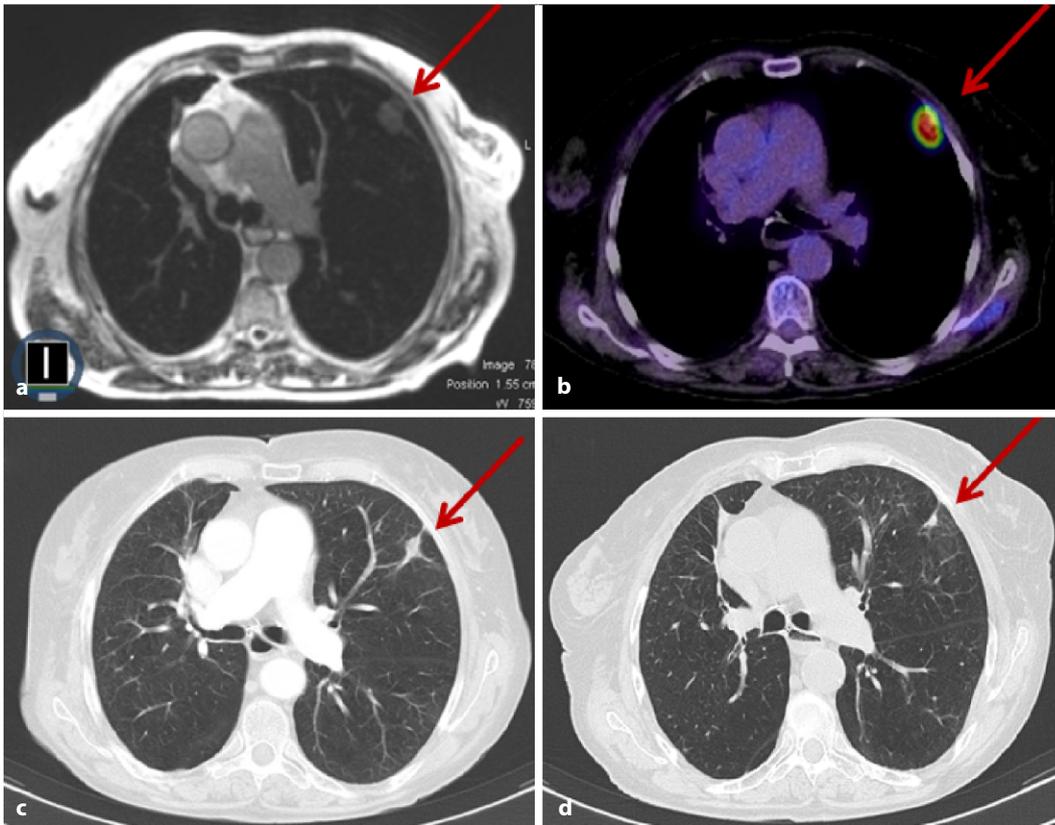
◀ Lung metastasis in the upper left lobe (red arrow): a True-FiSP at the MR-Linac for treatment planning; b fluoro-deoxyglucose positron emission tomography (FDG-PET) computed tomography (CT) for staging; c and d contrast-enhanced CT scan 3 months and 6 months after MR-guided radiotherapy of the lung metastasis
